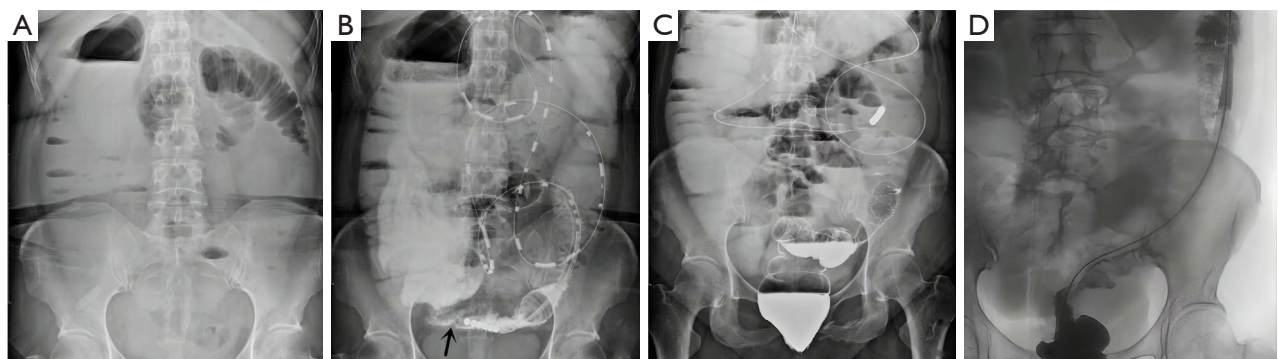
Patient 4 treatment course. (A) Multiple air-fluid level shadows arranged in steps on standing abdominal plain film 1 day before surgery; (B) intraoperative angiography of catheter insertion for nasal ileus, such as extraluminal pressure stenosis shown by the arrow, and the ileus catheter could not pass through; (C) air-fluid level shadows were not significantly reduced 3 days after surgery, the ileus catheter still could not pass through the stenotic segment, and local colon dilatation was significant; (D) transnasal ileus catheter insertion.
